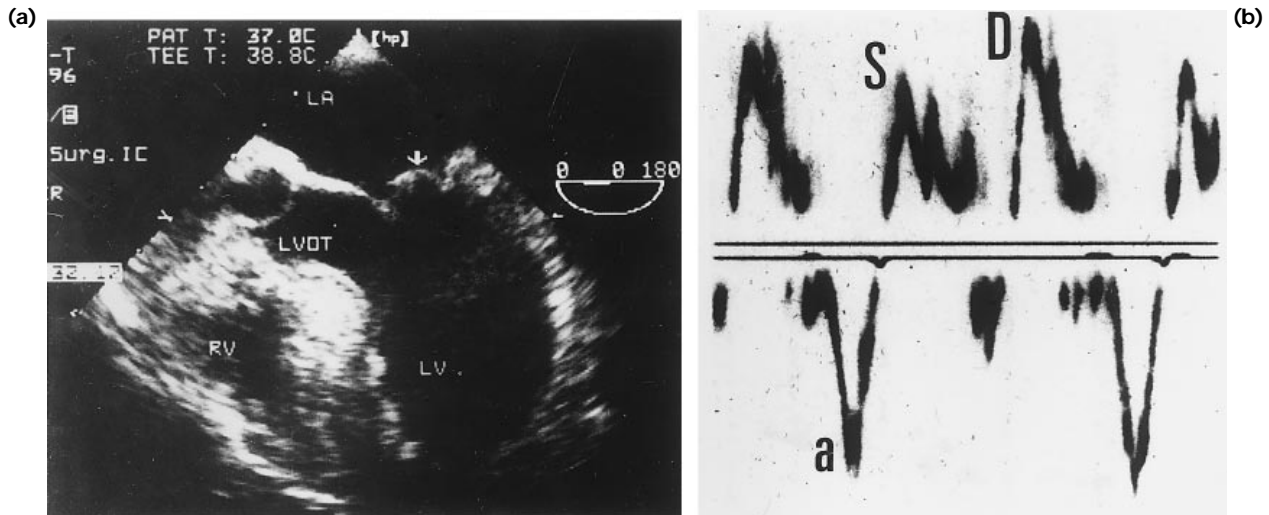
Left: visualisation of the mitral valve in transverse plane with a prolapse of the posterior leaflet of the mitral valve (arrow). Right: characteristic pulmonary vein Doppler pattern with a large negative flow wave (a: atrial contraction wave), a small systolic flow wave (S), a small negative flow wave (systolic reverse flow) and a larger positive flow wave (D).
